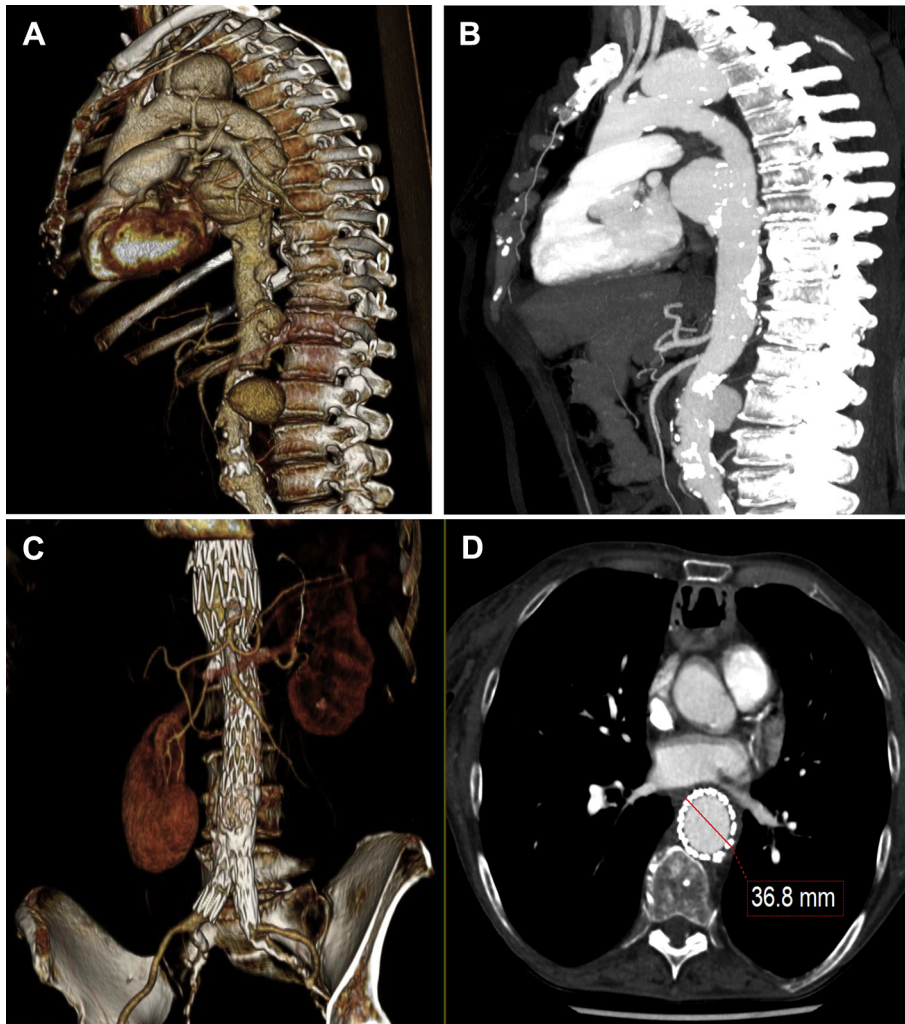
Computed tomography angiograms (CTAs) before stenting show multiple mycotic aortic aneurysms (MAAs) in (A) three-dimensional and in (B) maximum intensity pixel reconstructions. C, A three-dimensional CTA at 30 months shows patency of all the visceral vessels after quadruple-fenestrated stent graft repair. D, A CTA cross-sectional image at 30 months at the same level as Fig 1 shows a complete reduction in the size of the aneurysm.
